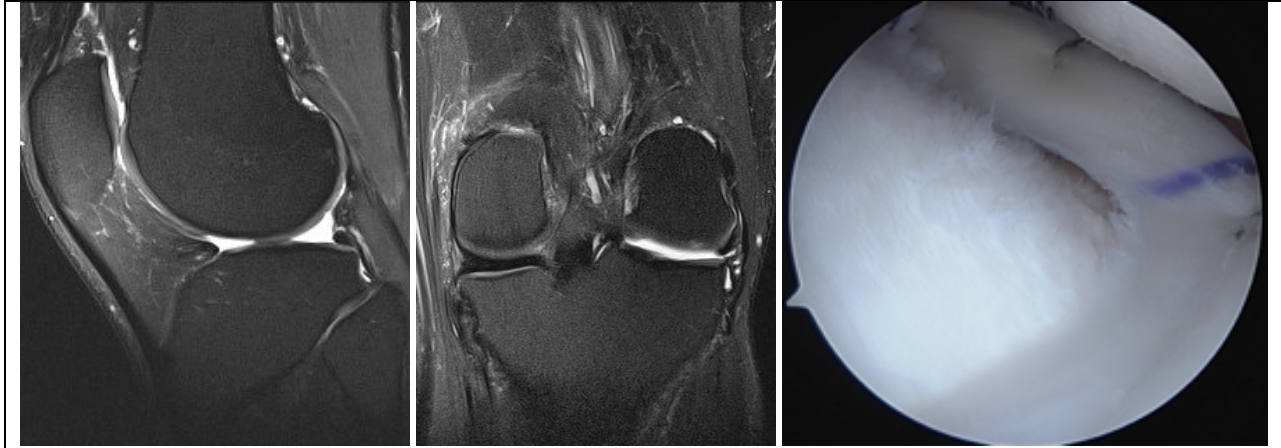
Sagittal (left) and coronal (middle) magnetic resonance imaging of the left knee shows absent lateral meniscus after previous subtotal lateral meniscectomy. The patient was treated with lateral meniscus allograft transplantation (right) using bone plug fixation.
